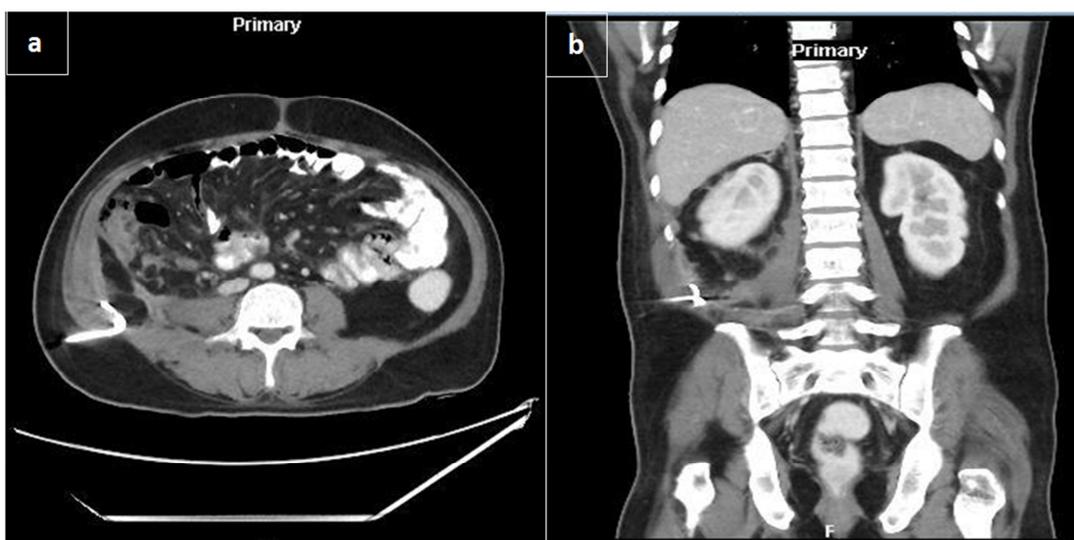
Abdominopelvic Computed Tomography (CT) with oral, rectal and IV contrast, (a) axial and (b) transverse plane, showing regressive course with few residual changes of post laparoscopy day#41.
